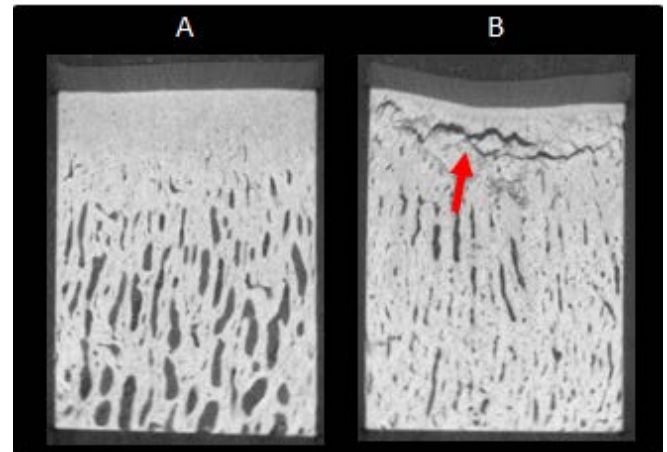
μ CT images of a sagittal cross-section of a typical undamaged (A) and damaged (B) cartilage-bone from distopalmar aspect of the MC3 condyle of a Thoroughbred racehorse.
